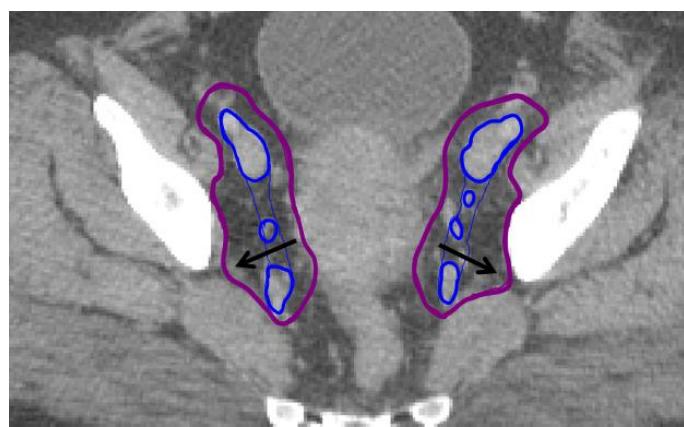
Axial CT of CTV2 extended laterally (in direction of arrows) to pelvic sidewall
